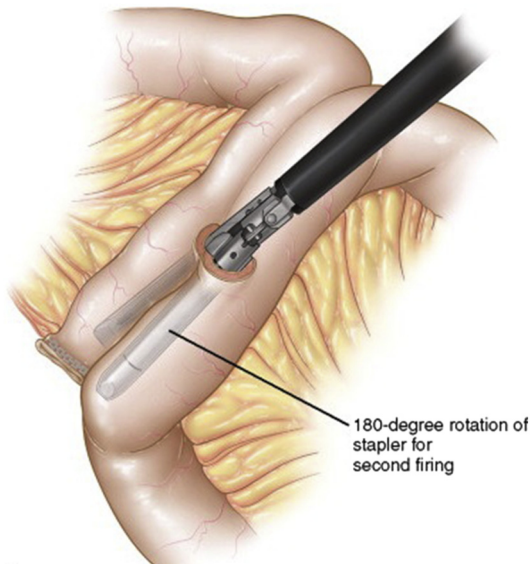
Second 2.5-mm white staple load is used to create the opposing staple line for the triple-stapling technique. (From Zografakis JG, Frantzides CT. Laparoscopic Gastric Bypass with Roux-en-Y Gastrojejunostomy. In: Frantzides CT, Carlson MA, editors. Atlas of Minimally Invasive Surgery. Philadelphia: Elsevier Saunders; 2009. p. 53–66; with permission.)
